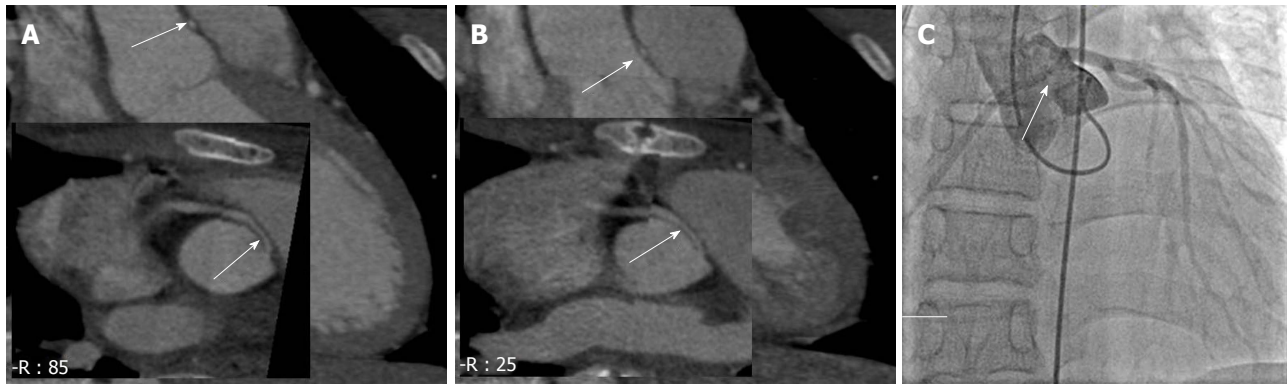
Coronary computed tomography shows coronary anomaly; right coronary artery from left coronary sinus running between aorta and pulmonary trunk causing functional stenosis of proximal segment (white arrow). A: Diastole state; B: Systole state. The coronary artery at diastole state is more occlusion. Coronary angiography (C, white line arrow) shows right coronary artery originated from the left sinus of valsalva and suspicious significant stenosis of right coronary artery ostium.
